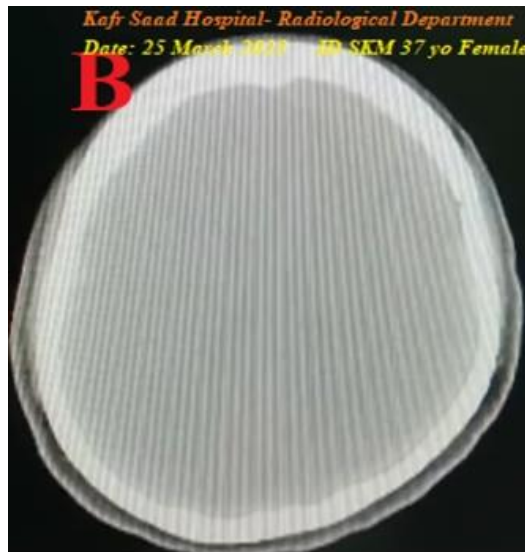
Brain CT was normal
